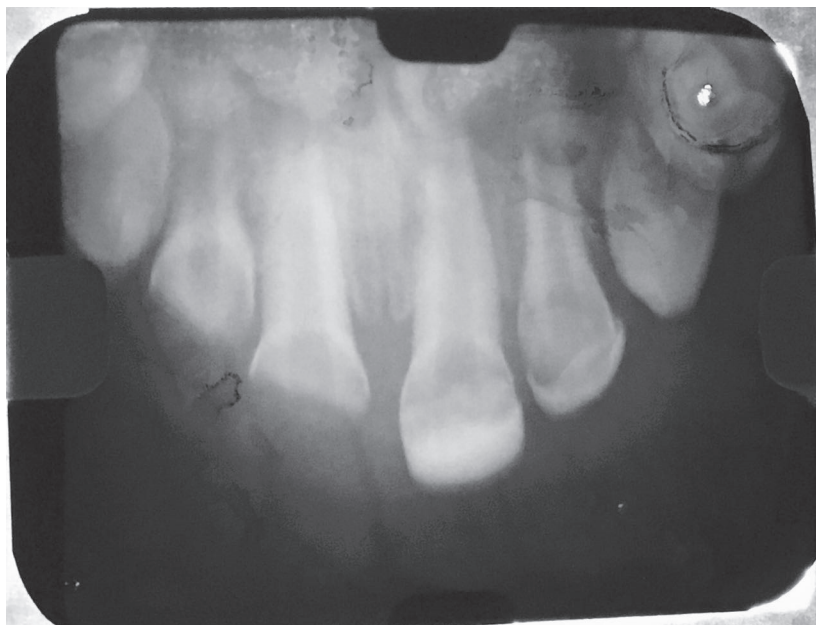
Initial radiograph - upper incisor.
